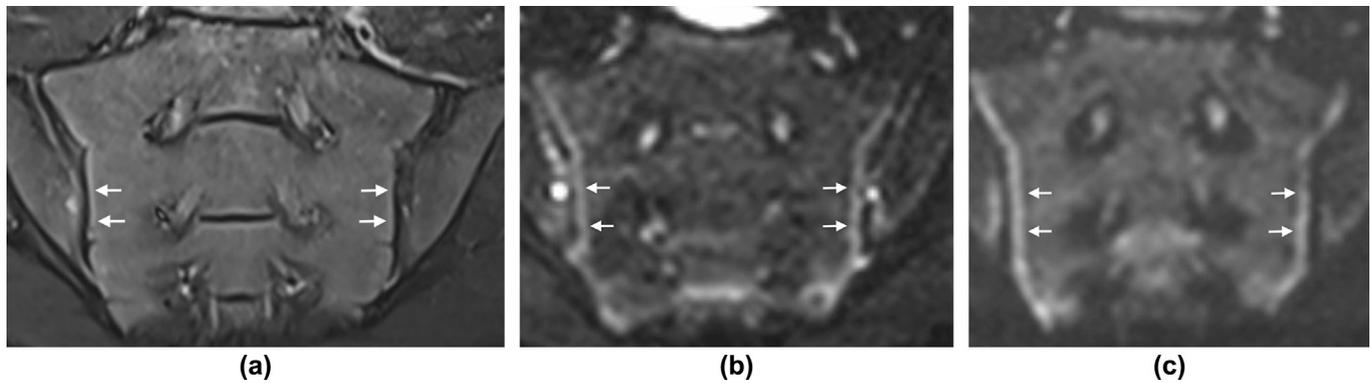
A 16-year-old boy with suspected sacroiliitis demonstrating the usefulness of DWI in demonstrating restricted diffusion of normal red marrow. (a) STIR coronal oblique image demonstrating linear high signal along the craniocaudal length on the sacral side of both sacroiliac joints related to cellular haematopoietic marrow (arrows). (b) Low and (c) high b-value DWI images in coronal oblique plane demonstrate increasing signal return along the sacral margin of the sacroiliac joint representing restricted diffusion due to high cellularity of haematopoietic marrow (arrows).
